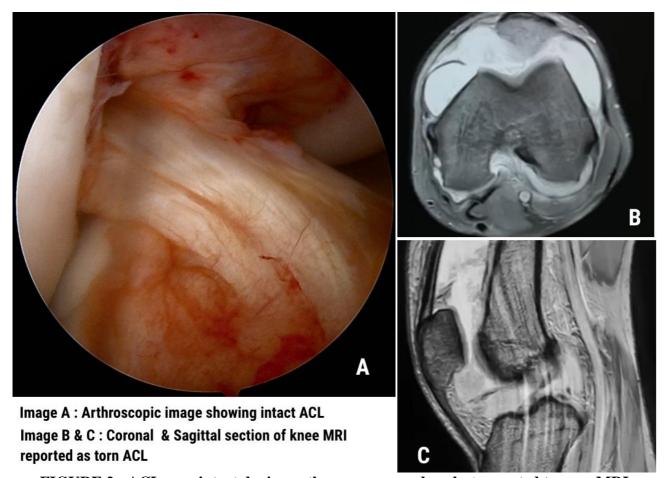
ACL seen intact during arthroscopy procedure but reported tear on MRI
